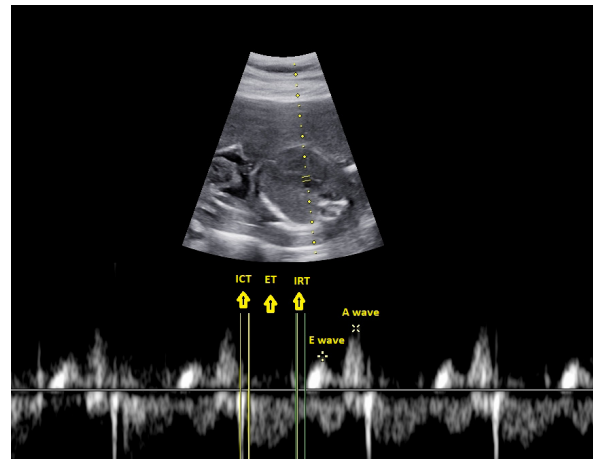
Doppler trace of isovolumetric contraction time (ICT), ejection time (ET), and isovolumetric relaxation time (IRT), and E wave/A wave peak velocities.
